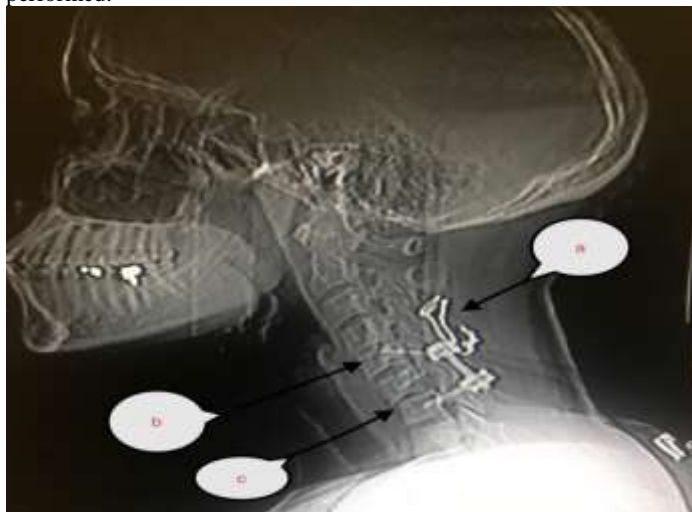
Lateral cervical spine X-ray showing final construct after treatment at her base hospital. Note the sublaminar wiring between C3 and C4 (a), and the lateral mass screws between C5 and C7 (b,c). Note the non-reduction of C6 on C7 (c).
